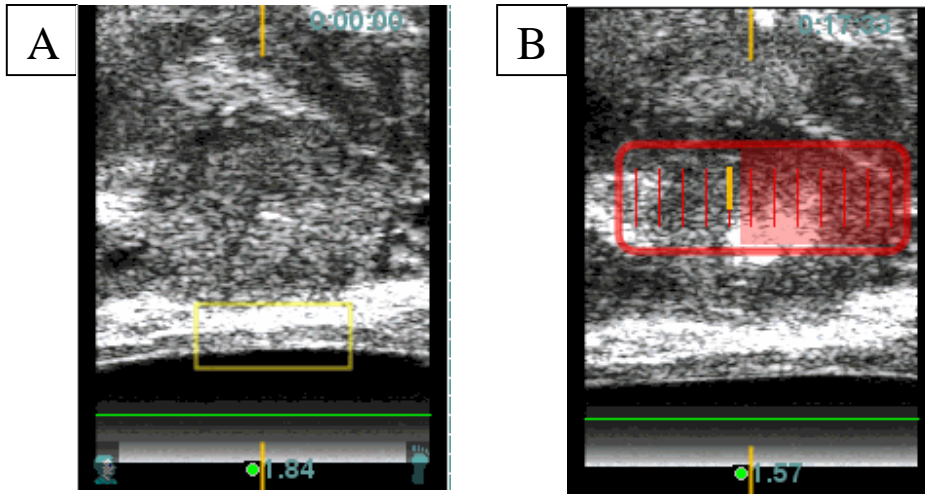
Grade III Uchida changes. Trans-rectal ultrasound image showing saggital plane through mid-gland of prostate. A: pre-treatment image, B: intra-operative image showing grey scale changes outside the treatment zone, extending into the near-field.
